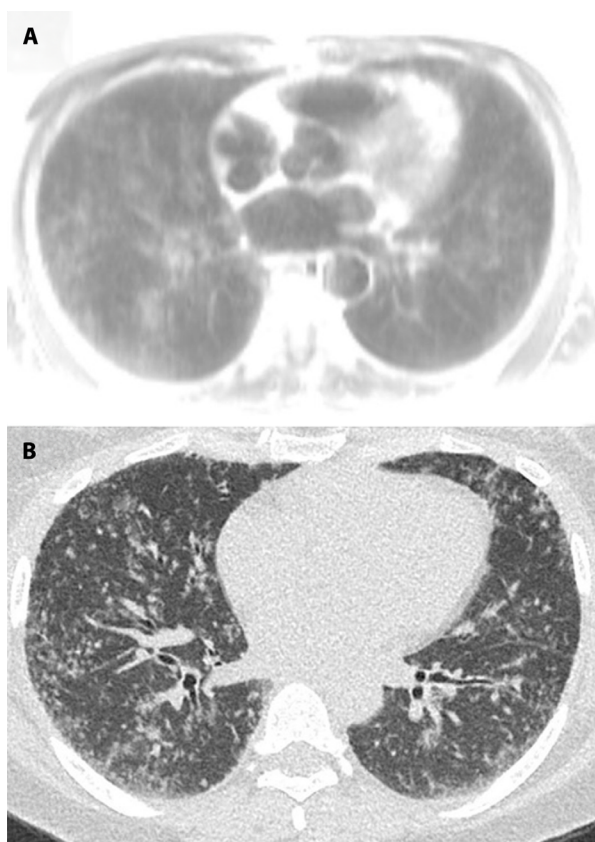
45-year-old woman with Stage II pulmonary sarcoidosis. Axial MR HASTE images (A) with corresponding chest CT image (B) show upper lobes perilymphatic micronodules consistent with pulmonary sarcoidosis.
